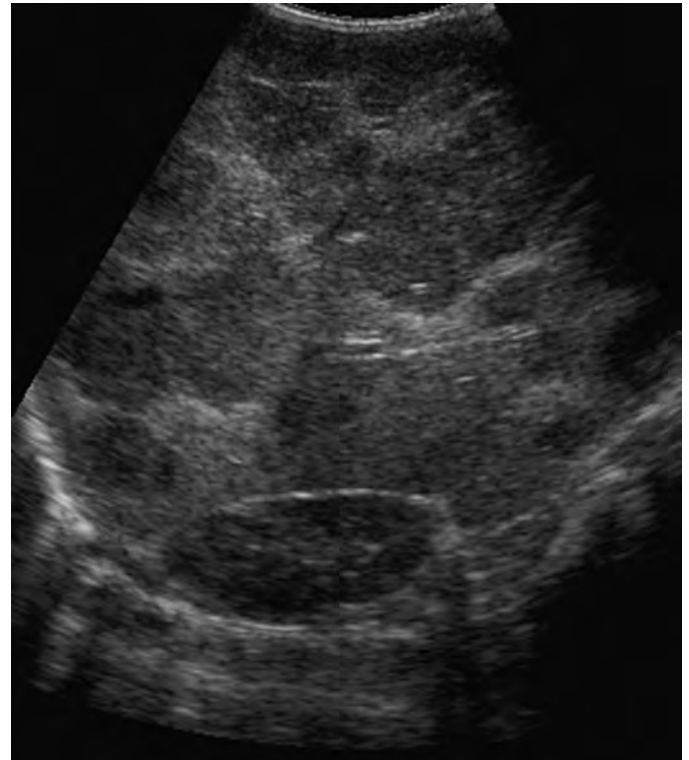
Hemangioendothelioma. Ultrasound of the liver in the sagittal plane in a 1-month-old girl with hepatomegaly demonstrates multiple, hypoechoic masses throughout the hepatic parenchyma due to multicentric hemangioendothelioma.
